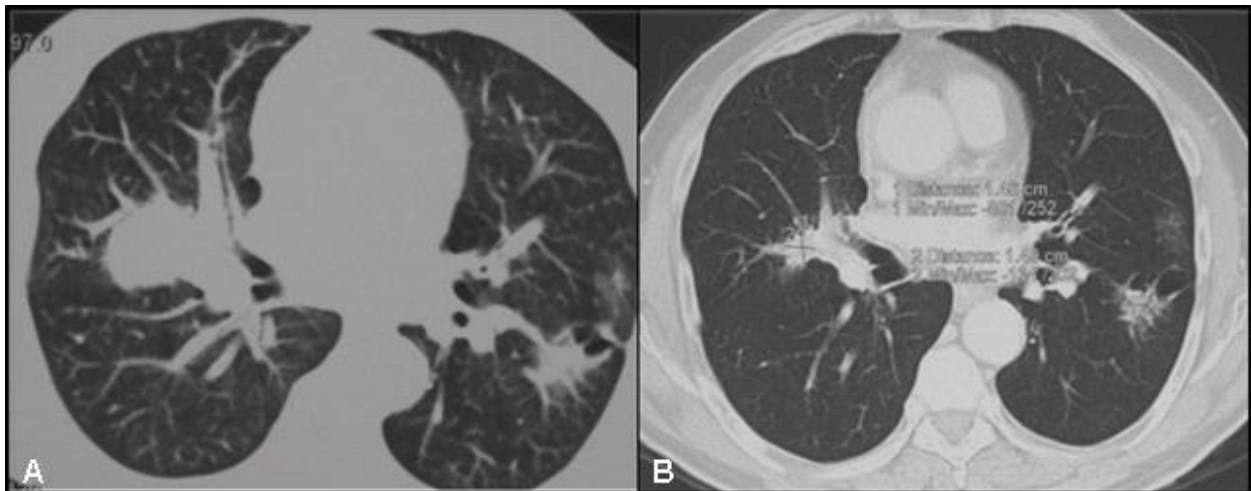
Evolution of tumor lesions after 6 months therapy with erlotinib as documented by CT scan. Panel A: thoracic CT scan, after chemotherapy. Panel B: thoracic CT scan after 6 months of therapy with erlotinib, 150 mg/die.
